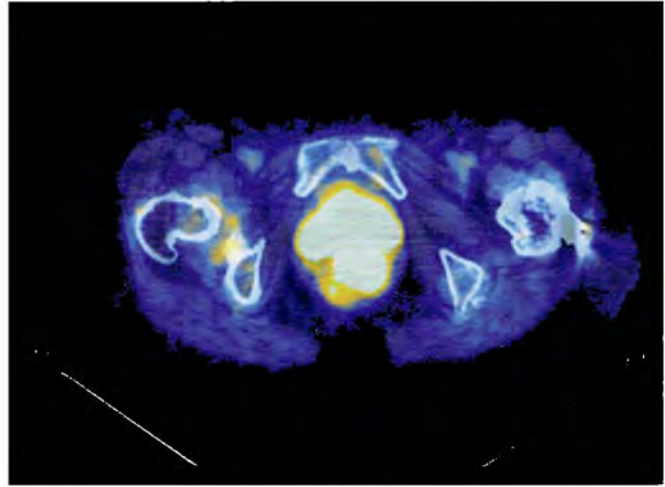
Superior and posterior to the bladder, a large cervical mass has intense FDG activity with a SUVmax of 19.6 g/mL. Otherwise, there is no regional or distant hypermetabolic lymph node metastasis.
